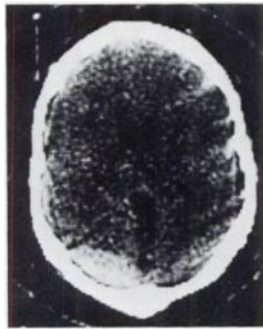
Cranial computed tomography depicting left occipitoparietal extradural hematoma.
